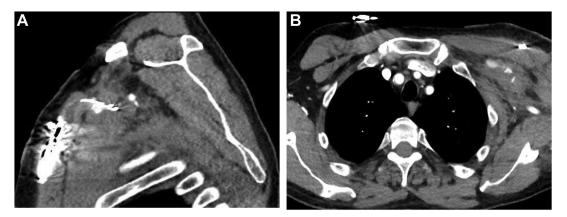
Computed tomography angiography to identify the location of bleeding. A: Sagittal section displaying active extravasation in proximity to the course of the pacemaker leads (highlighted in red circle). B: Axial section through area of active extravasation.
